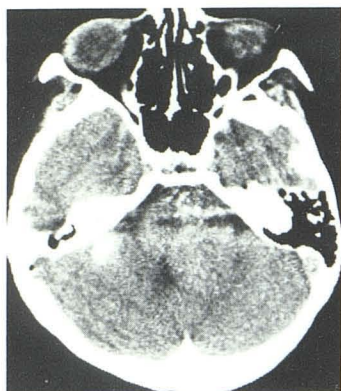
Brainstem glioma (status postradiation). A, CT after intravenous contrast administration depicts asymmetric enlargement of pons, displacement of fourth ventricle, and enhancing focus in right cerebellopontine angle. Note interpetrous beam hardening artifact. B, Axial NMR images show lesion in brainstem and cerebellum with greater contrast. Relatively higher intensity of left cerebellum compared with right and relative high intensity of lesion in right cerebellopontine angle. This is especially true on 56 msec sampling (right), which also shows extension of tumor into hypothalamus (*arrow*), when compared with 28 msec image (left). C, Two adjacent midsagittal sections depict pontine glioma and extent into hypothalamus (*arrow*).
